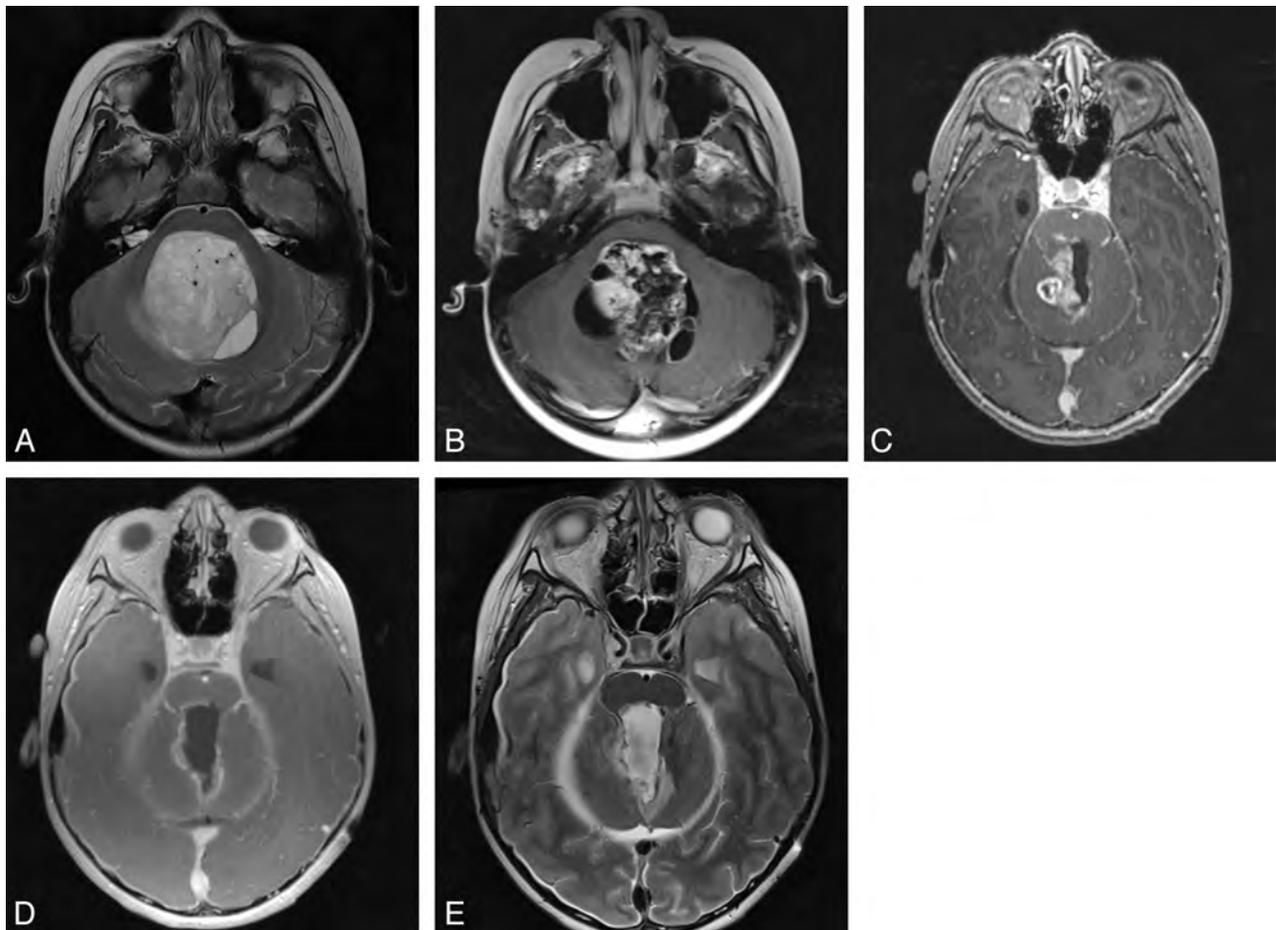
A, Axial T2-weighted image shows a mass in the fourth ventricle in a 9-year-old boy. B, Axial T1-weighted image after gadolinium administration shows heterogeneous enhancement within the lesion. C, Axial T1 postgadolinium image from intraoperative MRI shows residual tumor along the right superolateral aspect of the resection cavity. D, Axial T1 postgadolinium image from intraoperative MRI after continuation of resection shows removal of the previously seen residual lesion. A rim of enhancement was seen along the margins of the resection cavity; however, no discrete lesion was identified on surgical inspection of the margins. E, Axial T2WI shows a margin of T2 shortening with subjacent edema in the areas of enhancement, a pattern that corresponds to recent use of bipolar electrocautery. On this basis, no further resection was performed.
